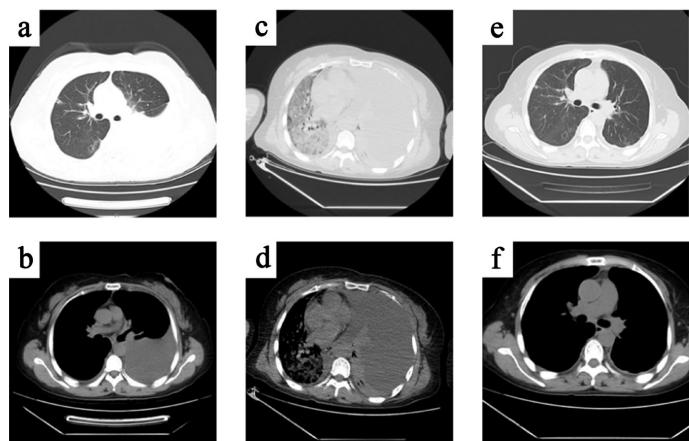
Chest CT findings at different time points during the diagnosis and treatment of the case. (a) (b) Prior to combination therapy, massive left pleural effusion is observed ((a) lung window; (b) mediastinal window). (c) (d) Three months post-combination therapy, diffuse pulmonary lesions with interlobular septal thickening in the right lung and persistent left pleural effusion are noted ((c) lung window; (d) mediastinal window). (e) (f) One week after treatment, near-complete resolution of right lung patchy consolidations and ground-glass opacities, along with marked reduction of left pleural effusion ((e) lung window; (f) mediastinal window)
